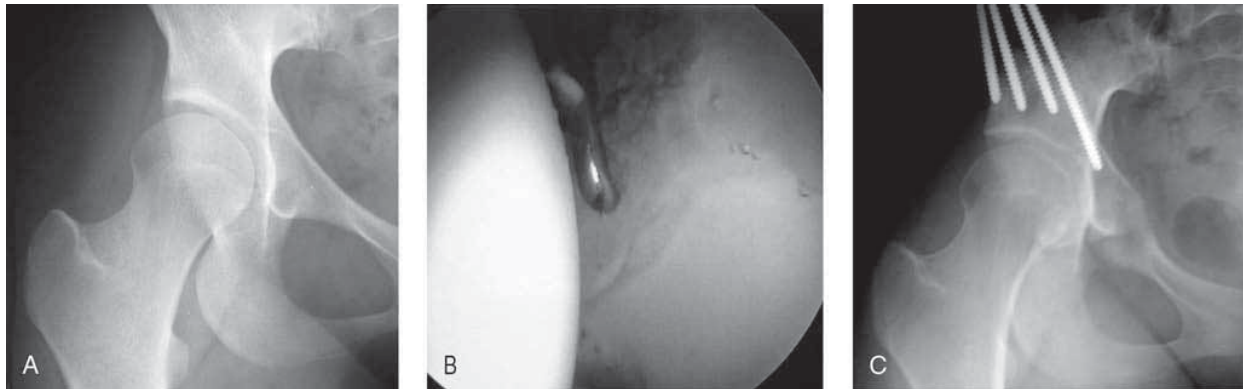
A, AP radiograph of the right hip in an 18-year-old woman with symptomatic acetabular dysplasia and intermittent mechanical symptoms of locking and catching. B, Hip arthroscopy reveals an intrasubstance unstable flap tear of the anterior acetabular labrum, which was treated with partial labral resection. C, A periacetabular osteotomy was performed to correct the structural deformity of the acetabulum. The patient had an excellent clinical result at 2-year follow-up.
